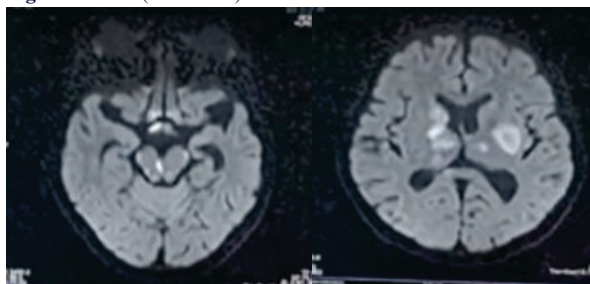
and 6(FLAIR MRI)
